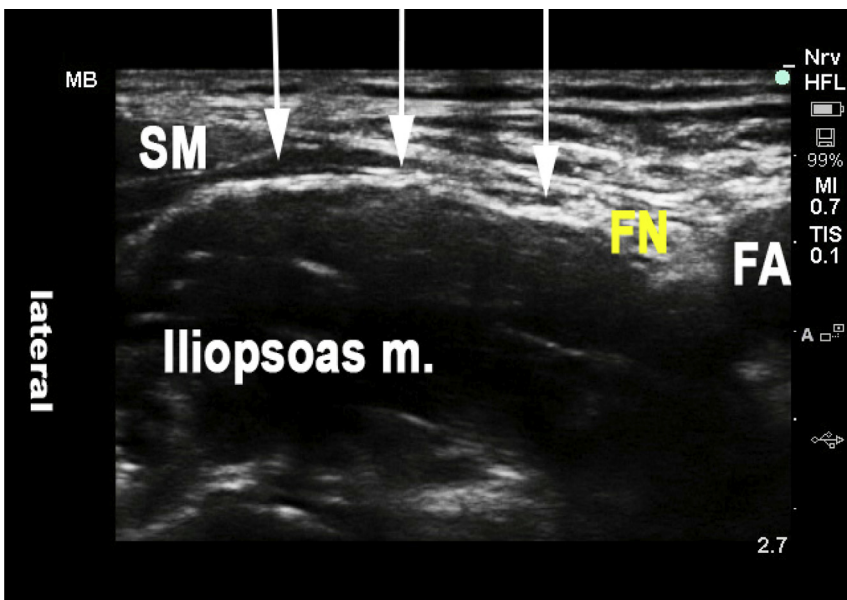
Ultrasound imaging showing landmarks for the fascia iliaca block. The sartorius muscle (SM) is typically triangular shaped and medially the femoral nerve (FN) is visualized deep to the fascia and lateral to the femoral artery (FA).
